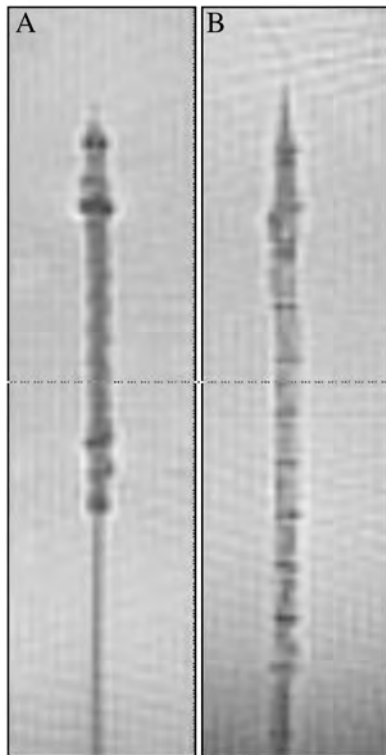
MRI-visualization of the delivery system with mounted stent-graft (A-GoreTAG, B-Evita).
